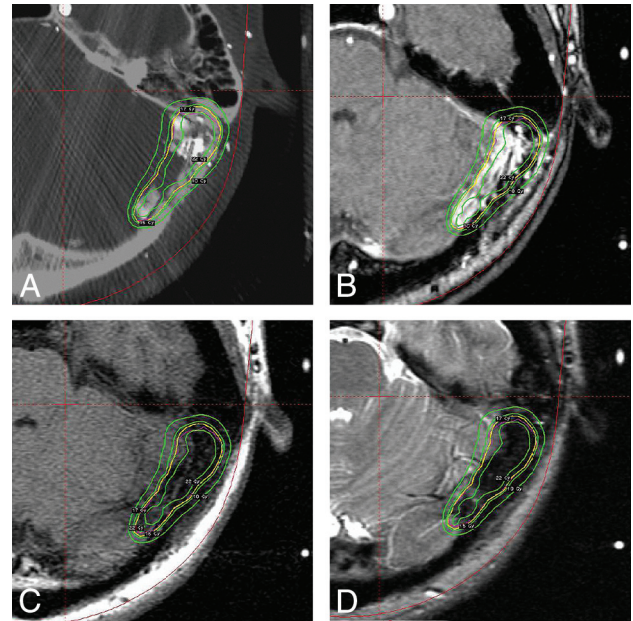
A, 4D-DSA of a 53-year-old man with a larger and more intricate AVM. The red arrow indicates a non-nidus territory, where it is considered part of AVM nidus based on the integrated MR images, enclosed within the irradiated volume. B, The corresponding TOF-MR imaging section. C, The T1-weighted MR image is shown on the same axial location. The nidus territory depicted by T1-weighted imaging is blurred. D, The T2-weighted MR image is shown on the same axial location. The T2-weighted MR imaging section provides clearer depiction of the nidus territory than the T1-weighted MR imaging because it does not show a flow void in the region in question.
